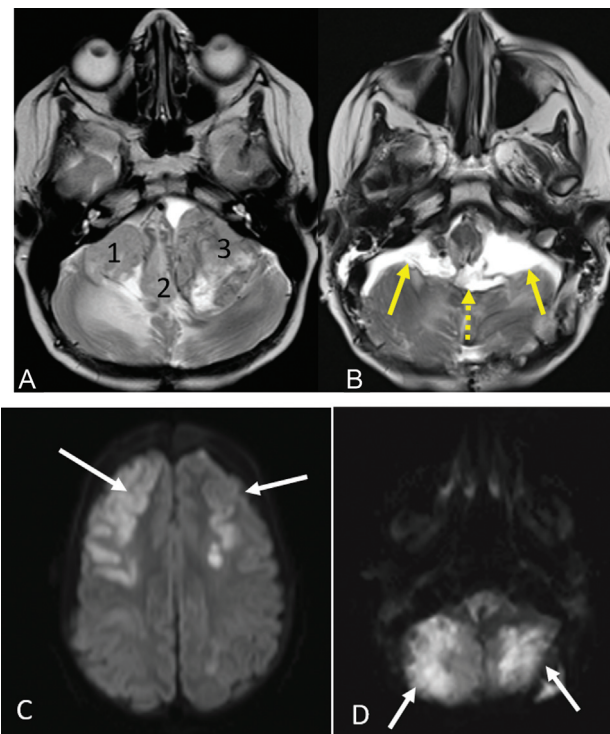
Preoperative and postoperative images. (A) Axial T2 sequence magnetic resonance imaging (MRI) showing midline (number 2) and bilateral cerebellopontine angle (CPA) (number 1 and 3) tumor. (B) Axial T2 sequence MRI showing totally resection of fourth ventricle (dotted arrow) and bilateral CPA (solid arrow). (C) Postoperative diffusion MRI showing bilateral vasogenic edema in frontal region. (D) Postoperative diffusion MRI showing bilateral vasogenic edema in cerebellum.
